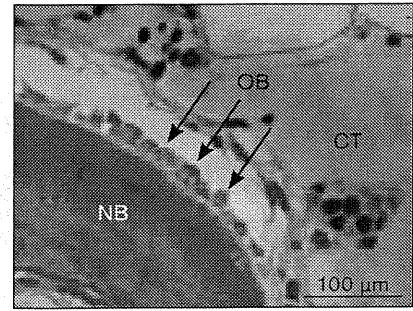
Higher magnification of the circled area in the lower part of Fig 3a (original magnification $\times 100$). NB = newly formed bone; CT = connective tissue; OB = osteoblast-like cells.
